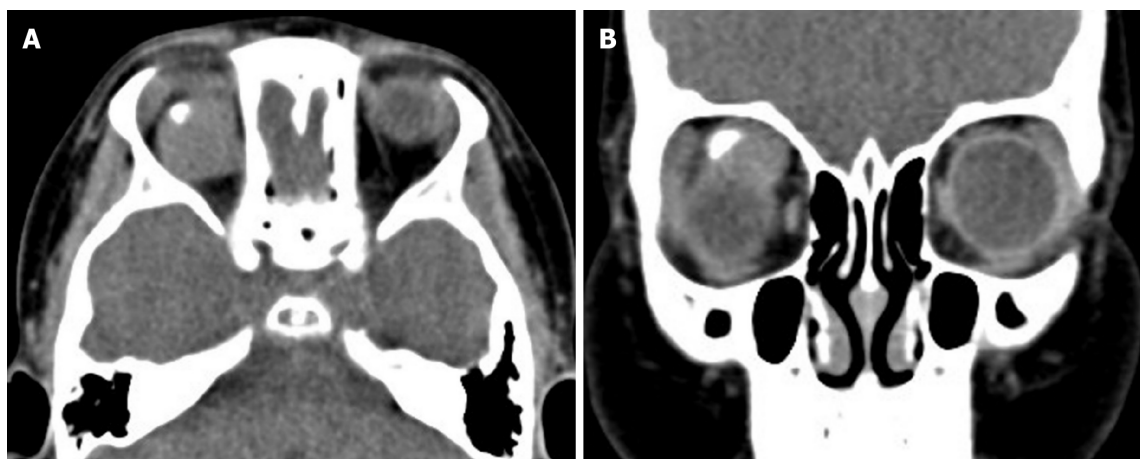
Orbital computed tomography scan showed a well-defined soft tissue density mass in the right orbit, with a hyperdense speck suggestive of coarse calcification. A: Axial computed tomography (CT) scans; B: Coronal CT scans.
